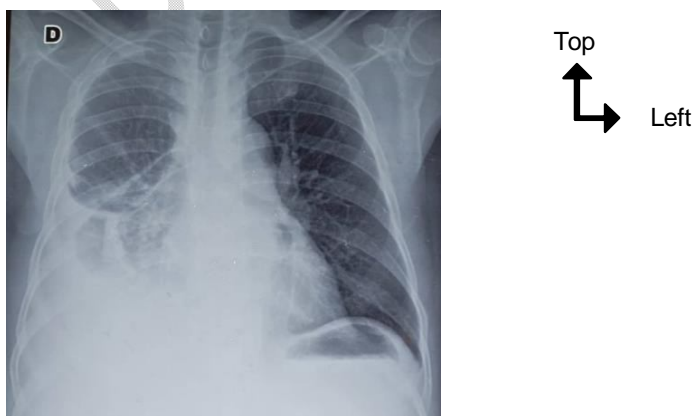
Front and upright chest X-ray showing favourable evolution of pleurisy on the right after placement of a chest drain (right basal homogeneous opacity filling the right cardiothoracic and cardiophrenic cul de sacs).
